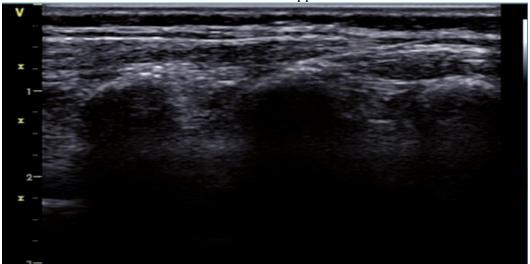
Ultrasound image for an erector spinae nerve block.
